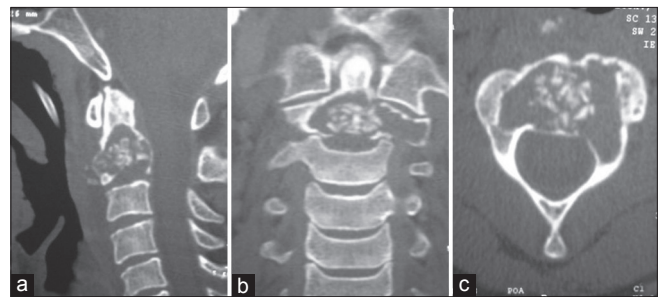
Post-operative. (a) Sagittal, (b) coronal and (c) axial computed tomography showing the cyst packed with crushed allograft
